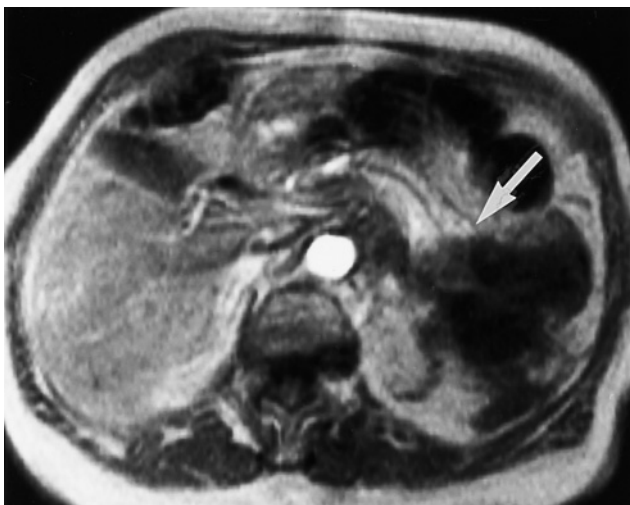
Mucinous cystadenocarcinoma. Immediate postgadolinium T1-weighted SGE image demonstrates a tumor arising from the tail of the pancreas (arrow) that contains thick septations and multiple large cysts. The tumor is locally aggressive and invades into the splenic hilum (not shown).
